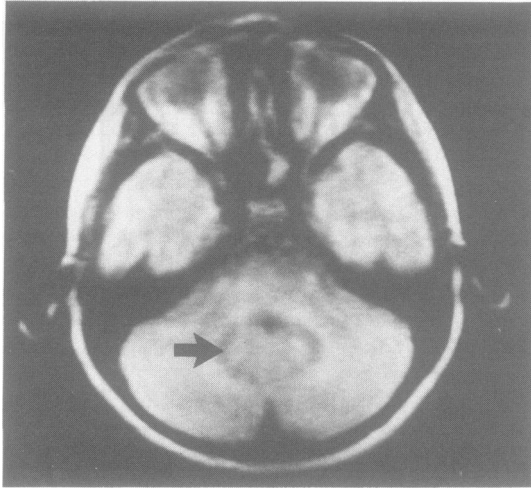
Axial spin echo MRI (TR 2000 ms, TE 40 ms). There are areas of abnormal signal seen symmetrically in the cerebellar hemispheres extending from the lateral aspect of the fourth ventricle curving laterally and posteriorly into the cerebellum. The abnormalities are of low signal (arrowed) with a surrounding zone of increased signal.
